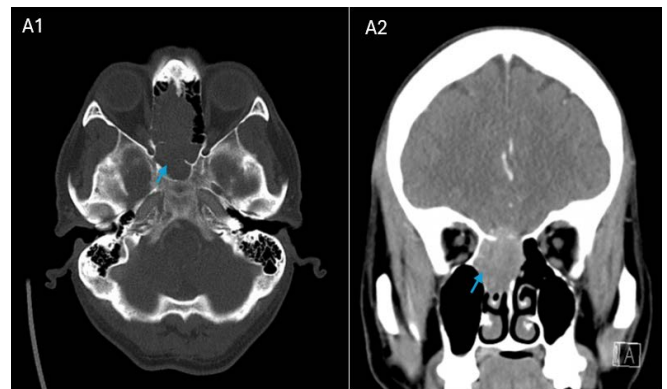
Axial (A1) and Sagittal (A2) views of CT of head and face with contrast at diagnosis (A1, A2) with contrast showed 2.9x 2.6x 5 cm mass = involving the right superior nasal passage, ethmoid air cells, and sphenoid sinus with local osseous destruction and septal resorption (marked by yellow arrow). It penetrates the cribriform plate with an intracranial component lying along the distribution of the right olfactory glove. No intra-axial infiltration of the right frontal lobe was noted.
